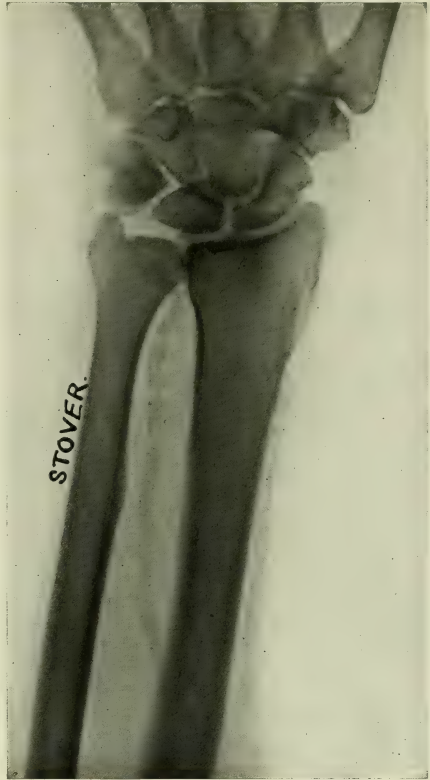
RADIOGRAPH SHOWING ARTERIOSCLEROSIS.
